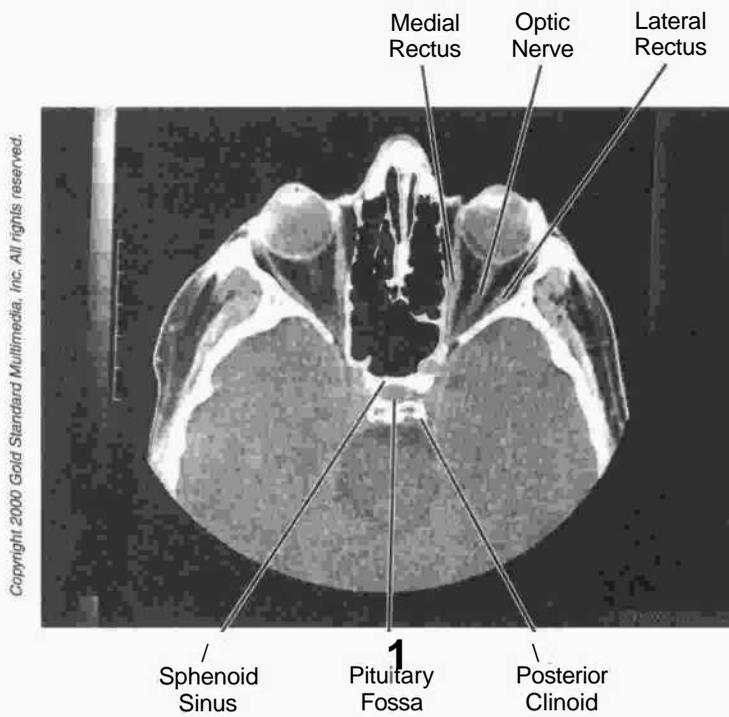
Head and Neck: CT, Orbit
